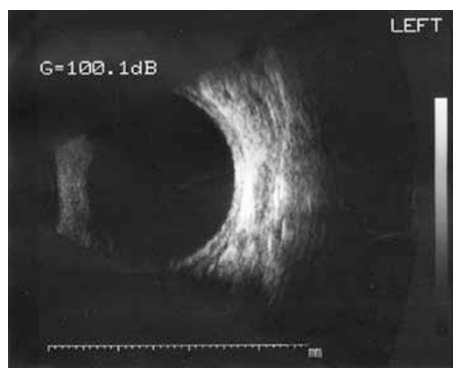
Left eye sonography showing choroidal thickening and choroidal effusion.
